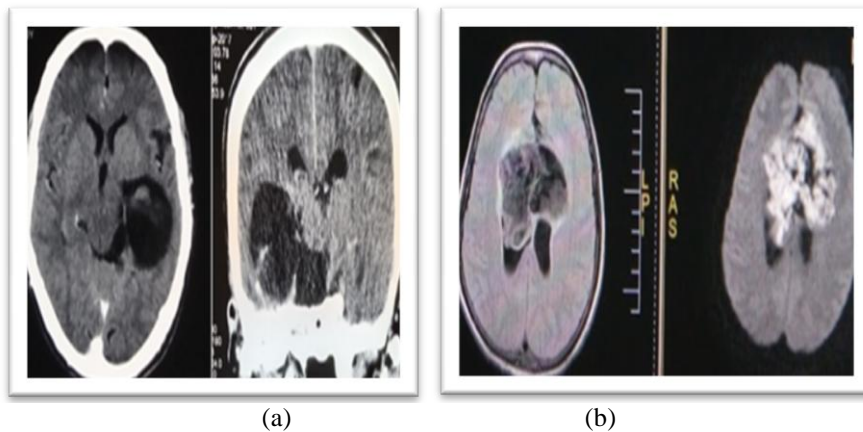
(a)CT axial and coronal depicts a hypodense insinuating mass located in CP angle in the image.(b) is MR picture of another patient with non enhancing hypointense mass in interhemispheric location which shows diffusion restriction characteristic of intracranial epidermoid.
